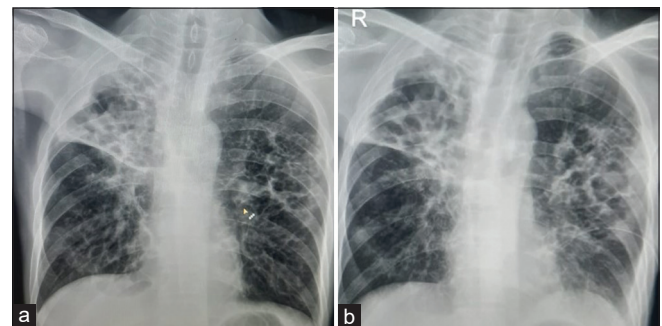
(a) Initial radiograph chest showing dense acinar radiopacities and cavitary lesions involving right upper zone, superior part of right middle zone and the left middle zone, suggestive of active pulmonary tuberculosis. (b) Radiograph chest obtained 05 months following institution of delamanid shows significant decrease in the lesions in the left middle zone
